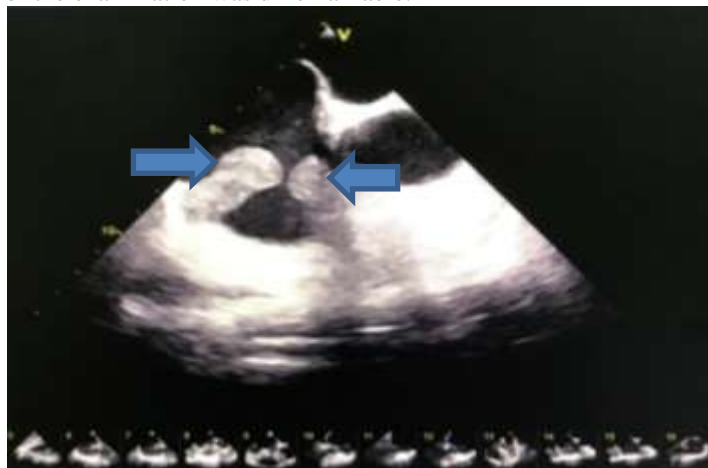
trans-esophageal echocardiography view showing the thrombi of the right ventricle.
